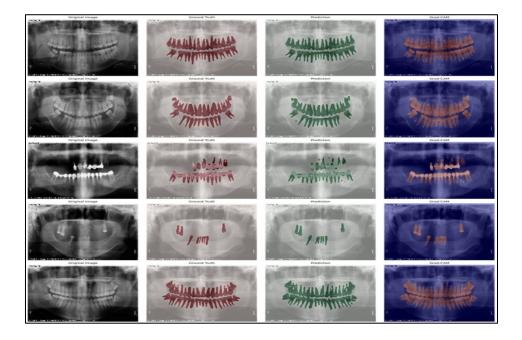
Comparative Visualization of Dental Panoramic Radiographs
